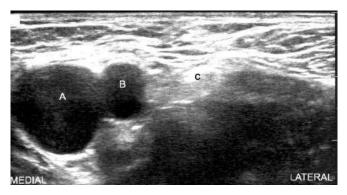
Ultrasound image of the brachial plexus at the location for the ISB. At this level, the roots of C5, C6, and C7 appear as hypoechoic circles between (A) the anterior and (B) middle scalene muscles, deep to the (C) SCM muscle.
